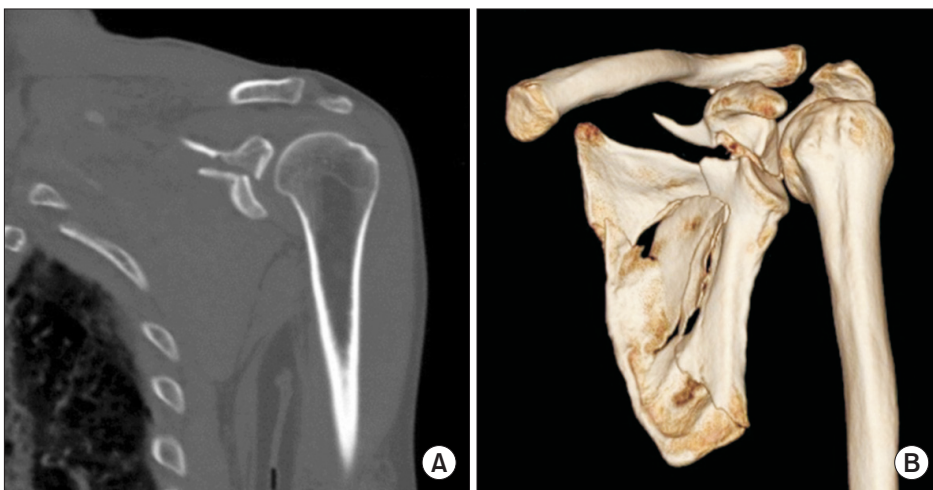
(A) Coronal cut of two dimensional computed tomography scan showing a displaced intra-articular glenoid fossa fracture with step off. (B) Three dimensional computed tomography scan showing a glenoid cavity fracture extending through the base of the coracoid process, type 3 glenoid fracture according to Ideberg classification, combined with a comminuted scapular body fracture.
